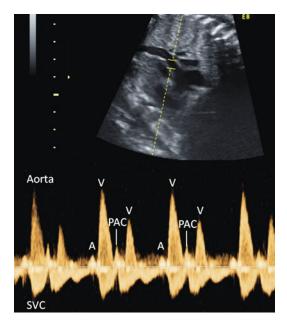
Pulsed Doppler tracing obtained using the SVC/Ao method which demonstrates conducted PACs. The sample volume is placed to include both the SVC and ascending aorta flows. With each premature atrial beat (*PAC*), conduction to the ventricle occurs, resulting in a premature ventricular beat (V)
